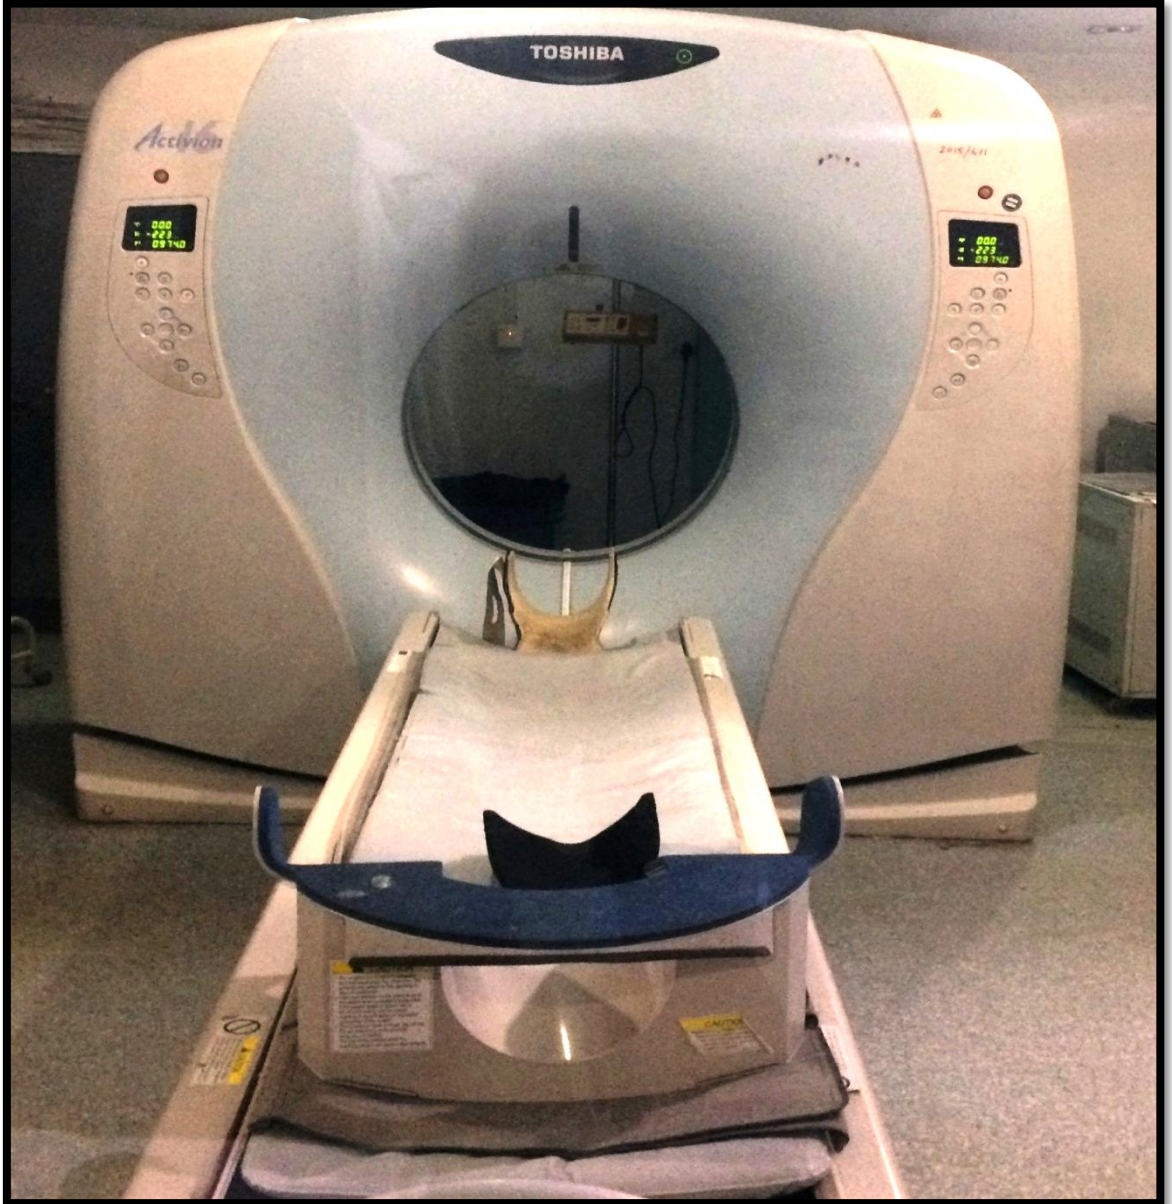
CT scan machine
